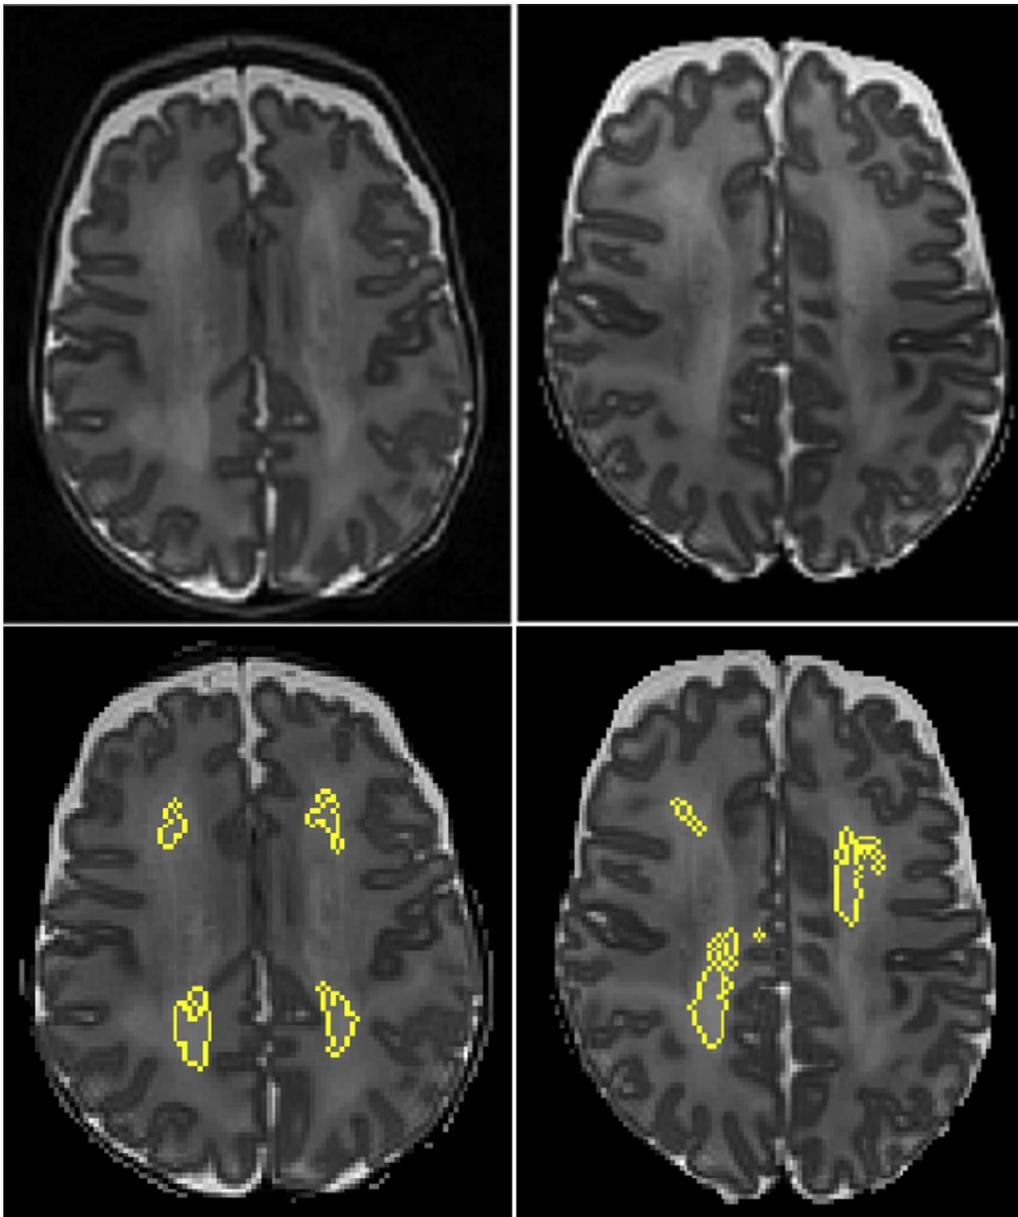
Semiautomated segmentation of diffuse white matter abnormality (DWMA) in the centrum semiovale. The two top panels display raw axial T2-weighted magnetic resonance images through the centrum semiovale (immediately above the lateral ventricles) from 27-week (left) and 31-week (right) gestational age preterm infants, scanned at term-equivalent age. Higher signal intensity can be appreciated in the centrum semiovale white matter from the surrounding subcortical white matter. The bottom panels display the corresponding slices with automatically segmented DWMA in yellow. Both infants were diagnosed with severe DWMA. The color version of this figure is available in the online edition.
